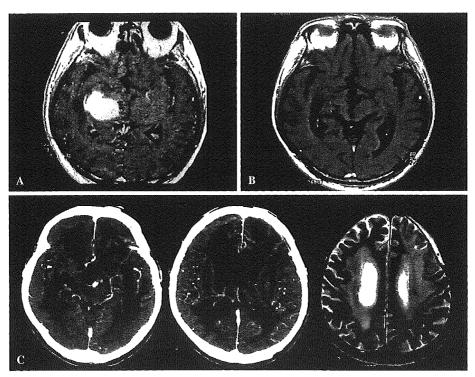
MRI and CT showing the progress after treatment with high-dose MTX and whole brain radiotherapy (40 Gy). Gd-enhanced MRI before the treatment (A), Gd-enhanced MRI at a month after the treatment (B), enhanced-CT scans (2 pictures on the left) showing complete remission of the tumor and ventricular dilatation, and T2-weighted MRI (right) demonstrating periventricular white matter hyperintensity consistent with leukoencephalopathy at 3.5 years after the treatment (C). The patient became demented about 3 years after the PCNSL treatment.
